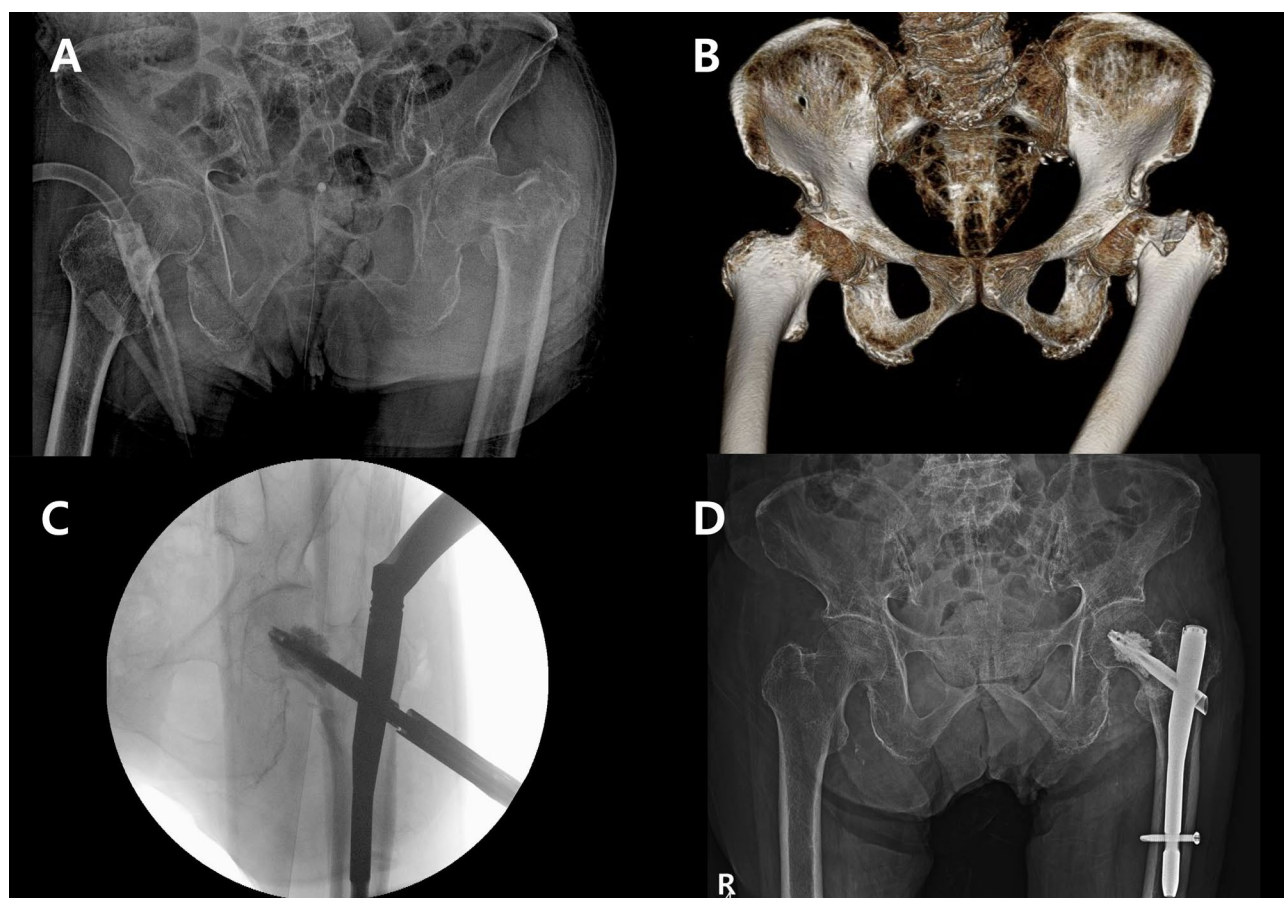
Case example of cement-augmented cephalomedullary fixation for a trochanteric fracture in a 97-year-old female A and B: preoperative plain radiograph and 3D reconstructed CT image, C: intraoperative view of cement augmentation, D: 1-year postoperative radiograph
